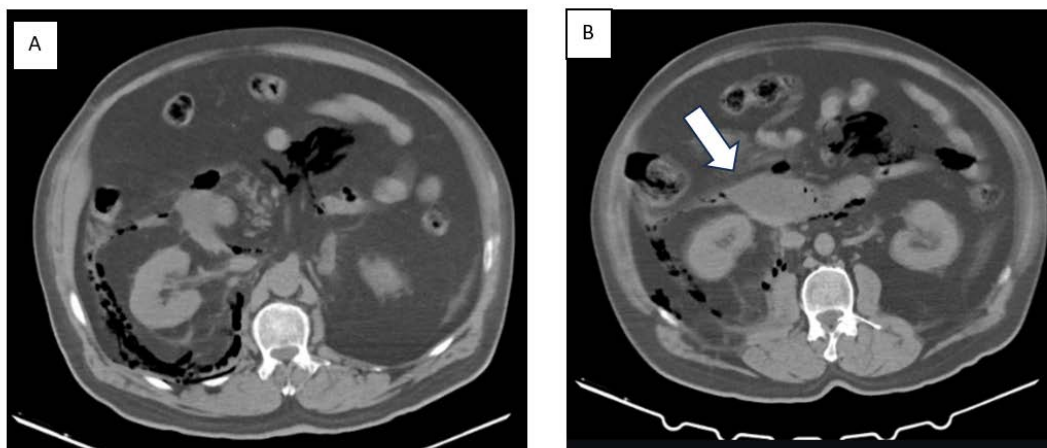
(A-B). A 60-year-old male patient, brought to the hospital 25 hours after the earthquake. Due to the patient's poor general condition and the presence of open wounds on the anterior and posterior abdominal walls, a non-contrast multidetector computed tomography examination was conducted. A. Intraperitoneal and right retroperitoneal free air was observed, likely due to penetrating injury to a hollow organ (stomach or duodenum). B. Additionally, fluid consistent with hematoma related to duodenal injury was observed around the duodenum (White arrow).
